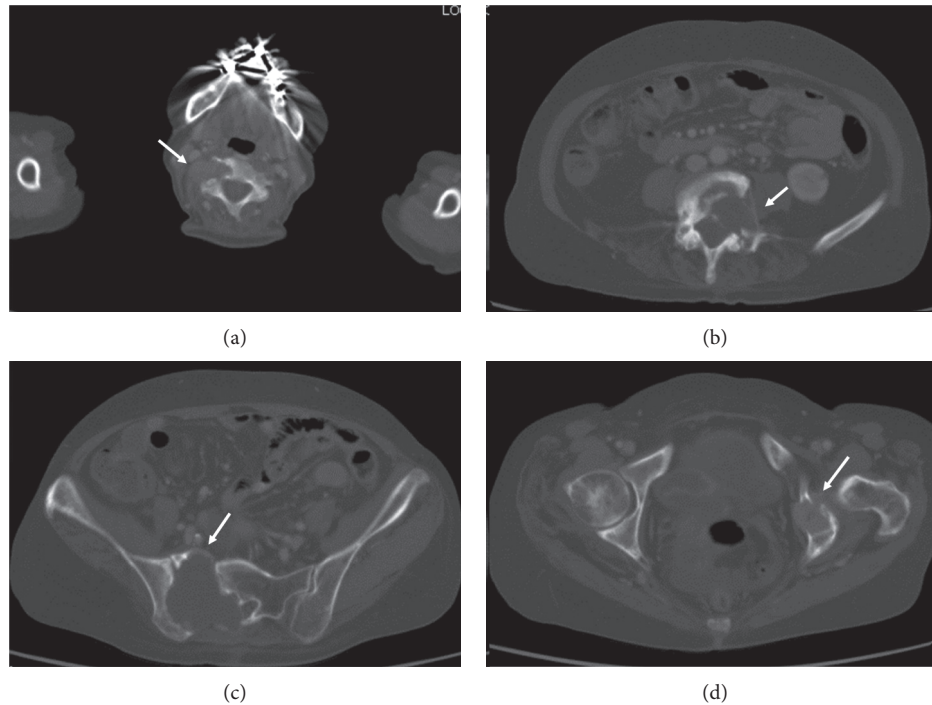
Computed tomography revealing bone metastasis (arrow). (a) C5, (b) L4, (c) S1, and (d) left acetabular cartilage.
